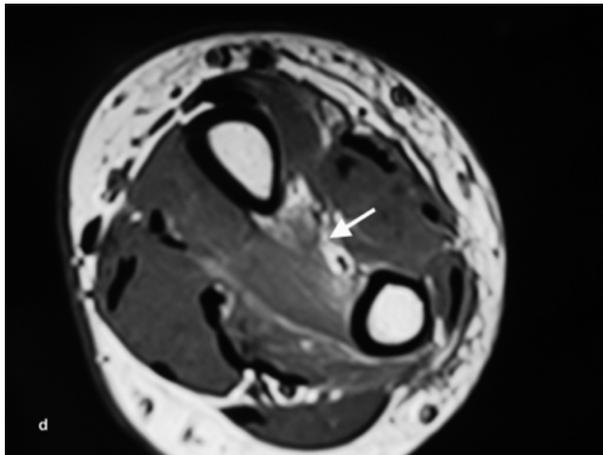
MRI imaging showing the loss of fiber continuity in the central region of the forearm (arrow)
